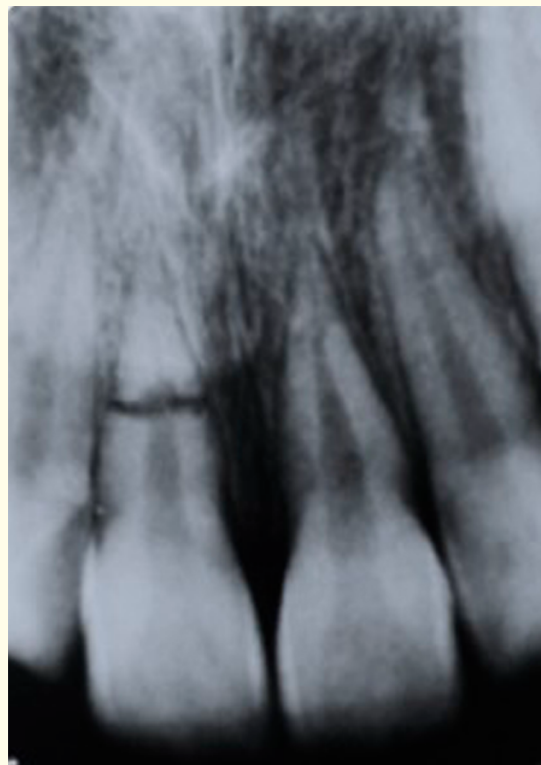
Periapical radiographic showing horizontal transverse root fracture in the middle third of the tooth 11.
